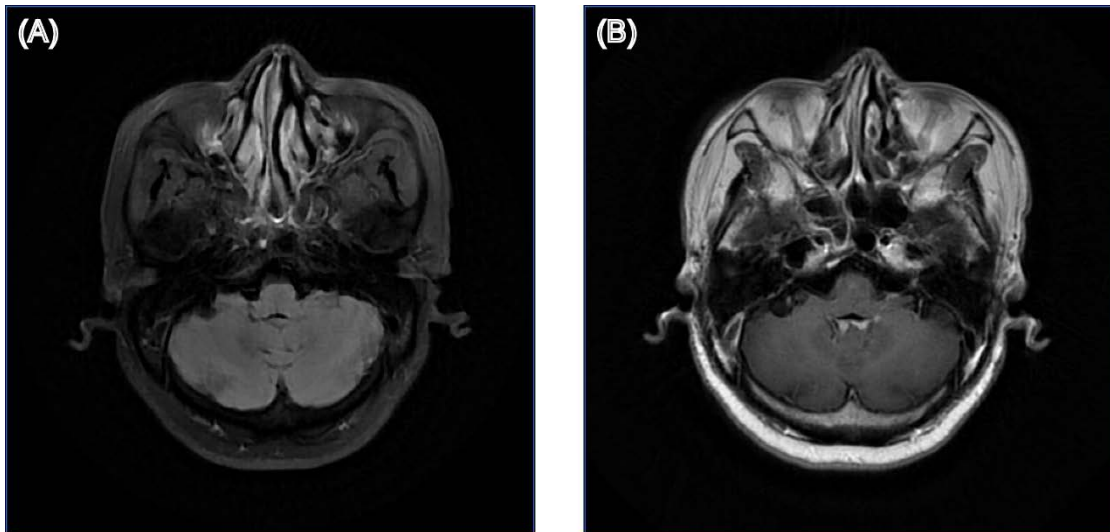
Structural brain MRI images of patient 18. (A) T2-weighted fluid-attenuated inversion recovery (T2-FLAIR) image; (B) Gadolinium-enhanced T1-weighted (Gd-T1w) image.
